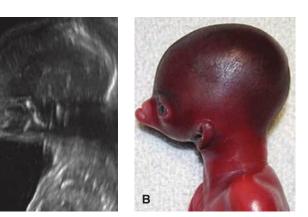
Agnathia-otocephaly, ultrasound (A) and postdelivery (B) images. With this rare, lethal anomaly the mandible fails to develop, and the ears are inferiorly displaced and may be fused in the midline.
